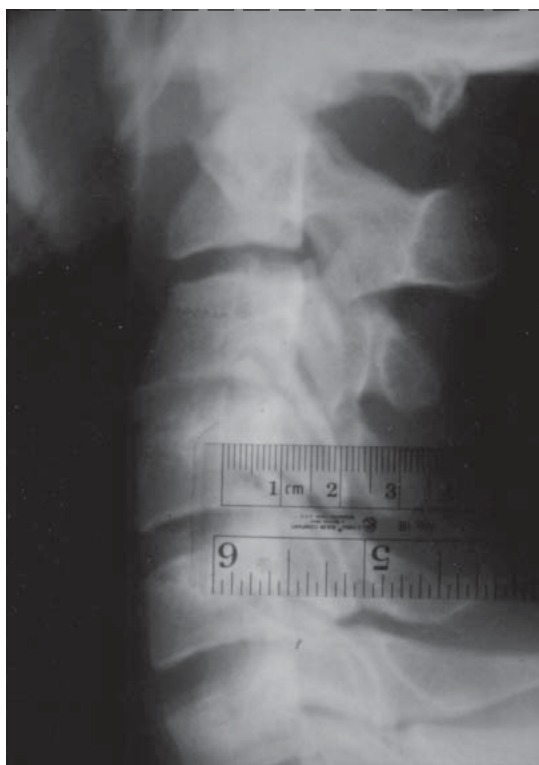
Congenital cervical stenosis. This 33-year-old male football player and All-Service safety became immediately quadriplegic after tackling a ball-carrier. Acute respiratory failure required emergent intubation and artificial ventilation. Note the congenitally narrow cervical canal with an anterior-posterior (AP) diameter of 12 mm. The Pavlov ratio, the ratio of the canal AP diameter to the vertebral body AP diameter, is 0.5; the lower limit of normal is 0.8. Roentgenograms also demonstrated anterior subluxation of C-3 on C-4, for which he underwent anterior discectomy and fusion. Over several weeks, the patient recovered sufficient diaphragm movement to wean from the ventilator. Over six months, he regained sufficient lower extremity movement to be independent in ambulation with a single point cane. He also experienced good recovery in his left upper extremity such that he became independent in self-care skills; his right upper extremity remained nonfunctional. Voluntary bowel and bladder control returned.
